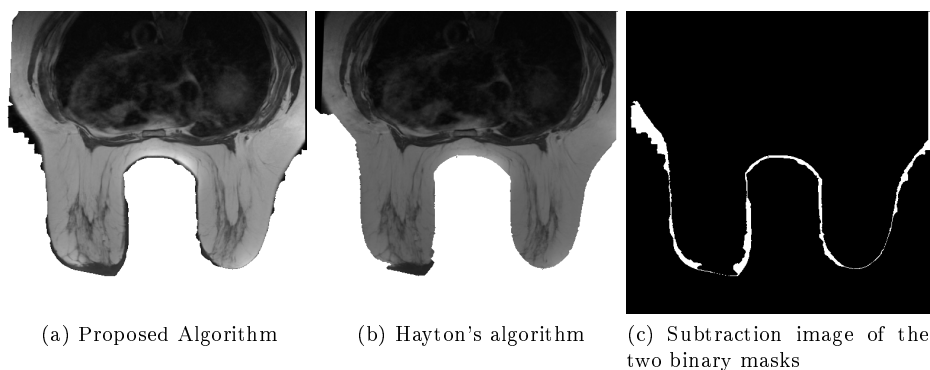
Comparison between Hayton Segmentation and Proposed Algorithm for T1-weighted images.
